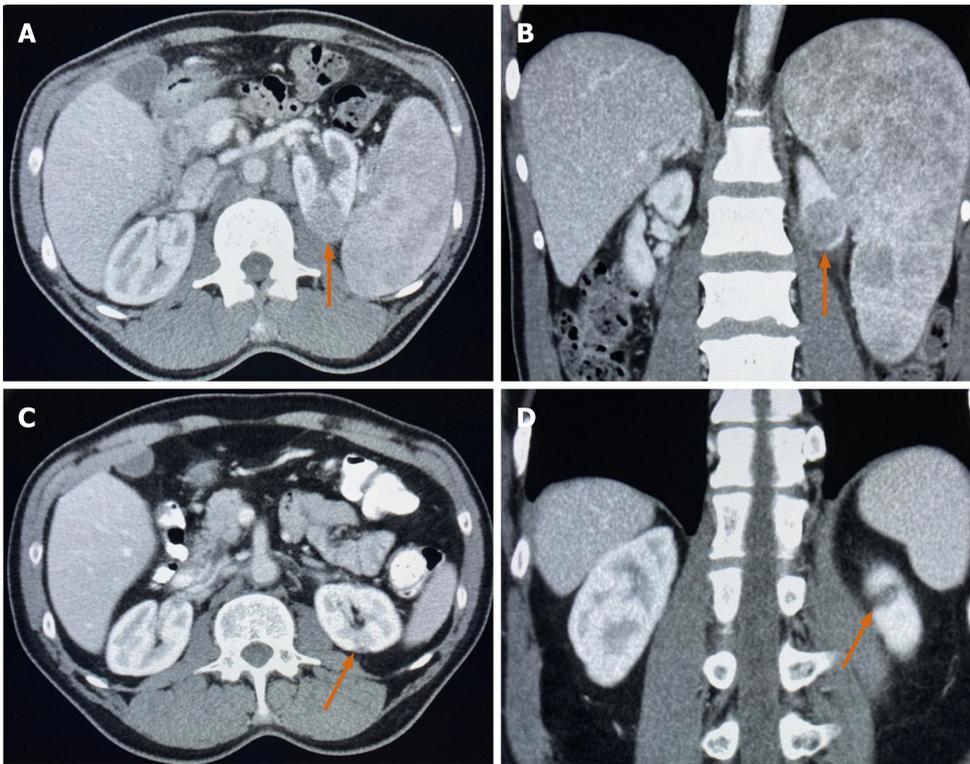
Computed tomography imaging. A and B : Case #1: Computed tomography imaging revealed a renal mass (arrows). Biopsy of the mass was consistent with papillary renal cell carcinoma; C and D: The renal mass resolved after treating the follicular lymphoma with 6 cycles of bendamustine/rituximab (arrows).
